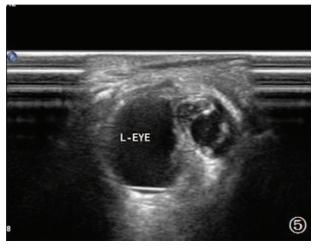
Postnatal 2-dimensional ultrasound image of the left eye: the shape of right eye is abnormal. The structures appear disordered and a crystalline lens cannot be observed in the orbit.
